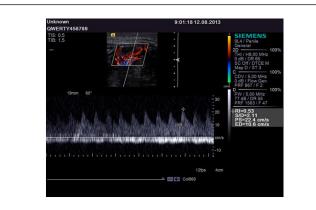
Echogram of the intestinal loop in a neonate, day 2 postop (pulsed-wave Doppler scanning). Evalution of peripheral resistance in the bowel wall vessels.
